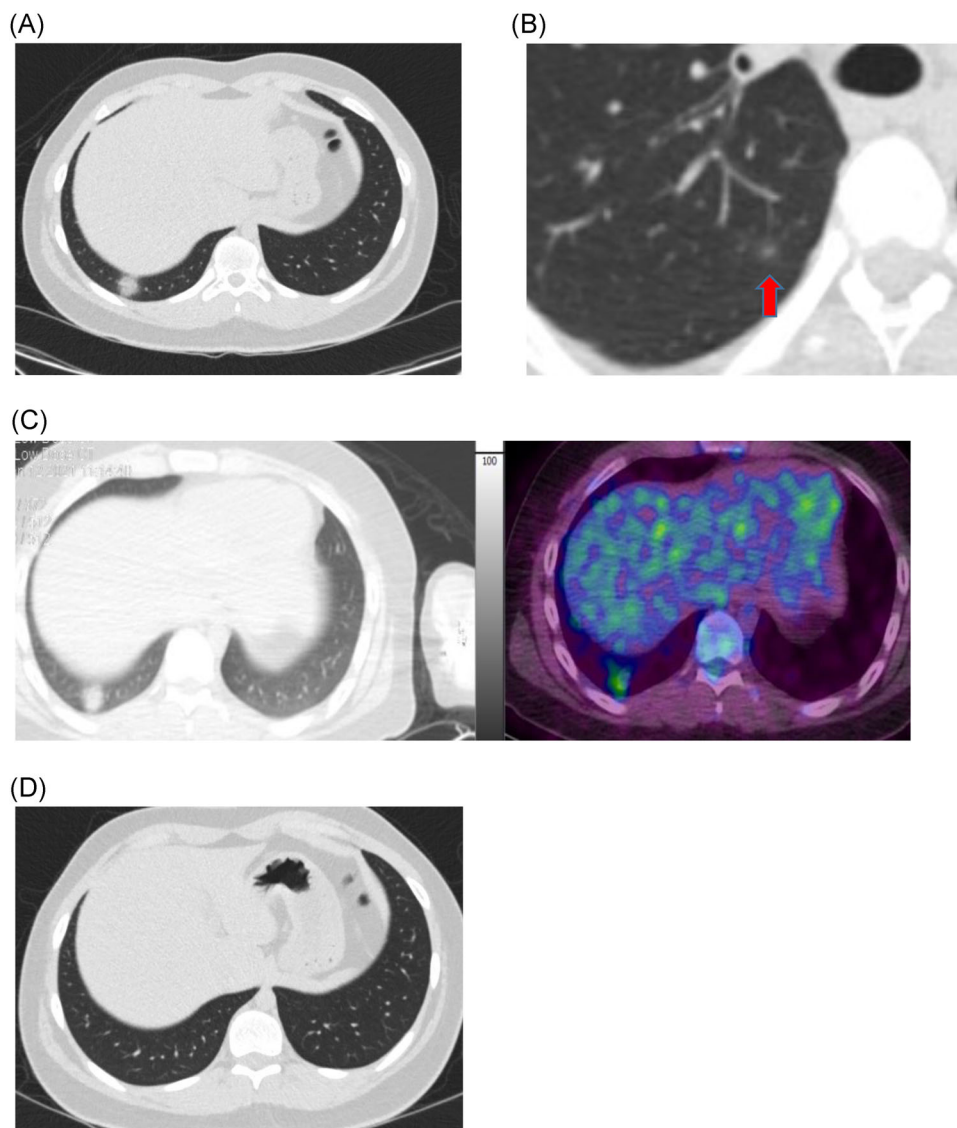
(A) Computed tomography (CT) chest demonstrating new 1.7 cm ground glass nodule within the right lower lobe. (B) CT chest demonstrating new 4 mm ground glass nodule (demonstrated by arrow) within the right upper lobe. (C) Positron emission tomography (PET)/CT done with CT chest (A and B) demonstrating new right lower lobe pulmonary nodule with moderate fluorodeoxyglucose (FDG) uptake, suspicious for metastasis. (D) CT chest demonstrating resolution of the previously seen ground glass nodule
